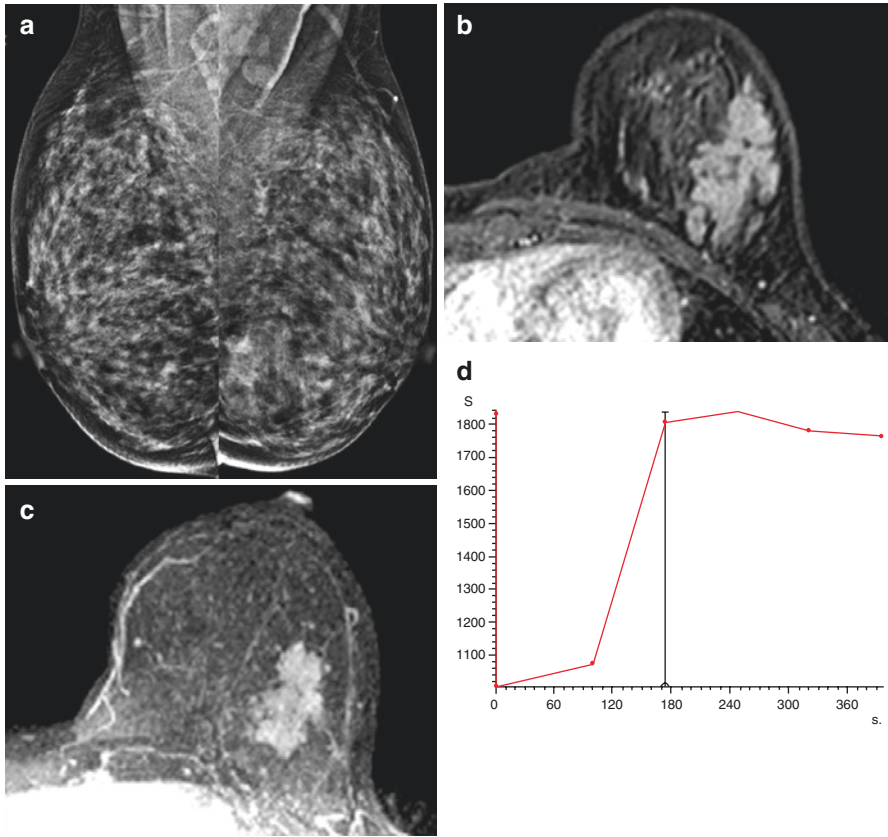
Noncalcified grade 2 DCIS: mediolateral oblique mammogram (a) shows architectural distortion asymmetry in the lower part of the left breast, which corresponds on axial contrast-enhanced (b) and maximal intensity projection (c) MR images to a region of clumped nonmass-like enhancement. The kinetic curve of this lesion (d) demonstrates early enhancement with plateau (type 2 kinetics)
